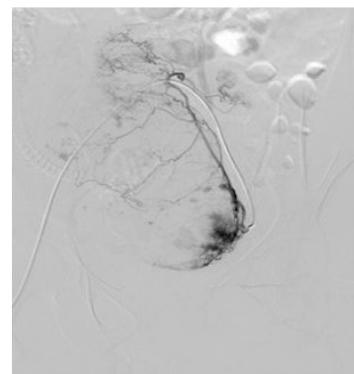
Radiologists did femoral artery puncture and radiography, placed balloon.
